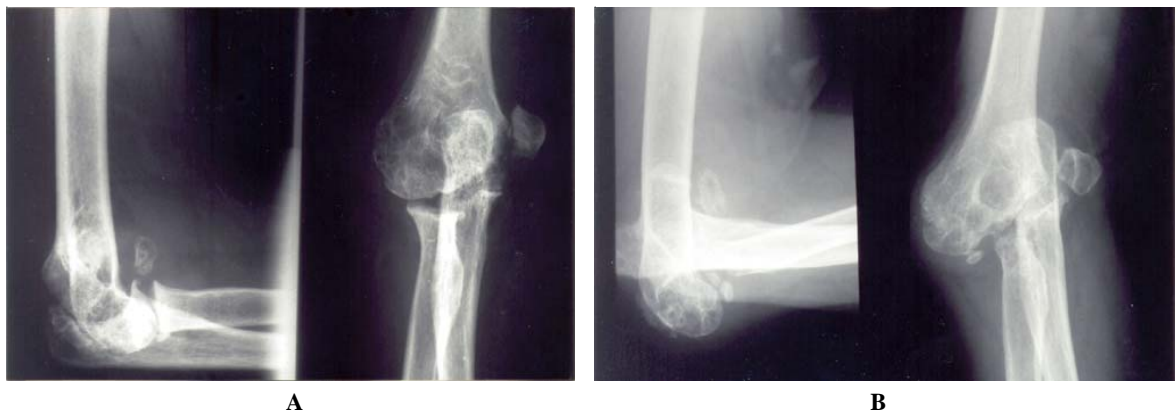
Anteroposterior and lateral radiographs of the left elbow
